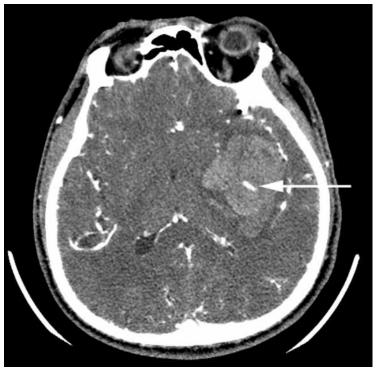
The "spot sign" (arrow), contrast extravasation after contrast-enhanced computed tomography, is associated with a high risk of hematoma expansion.
